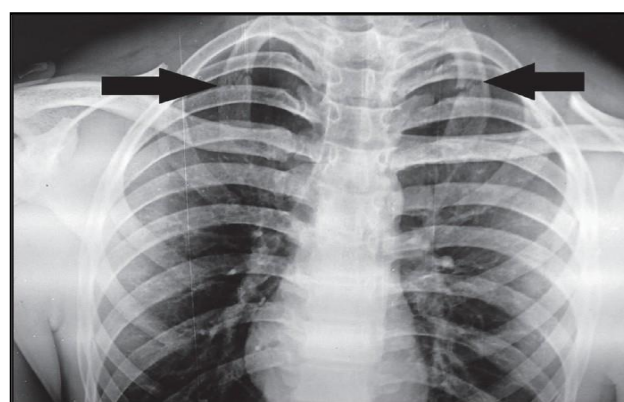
X-ray showing B/L first rib fracture.
